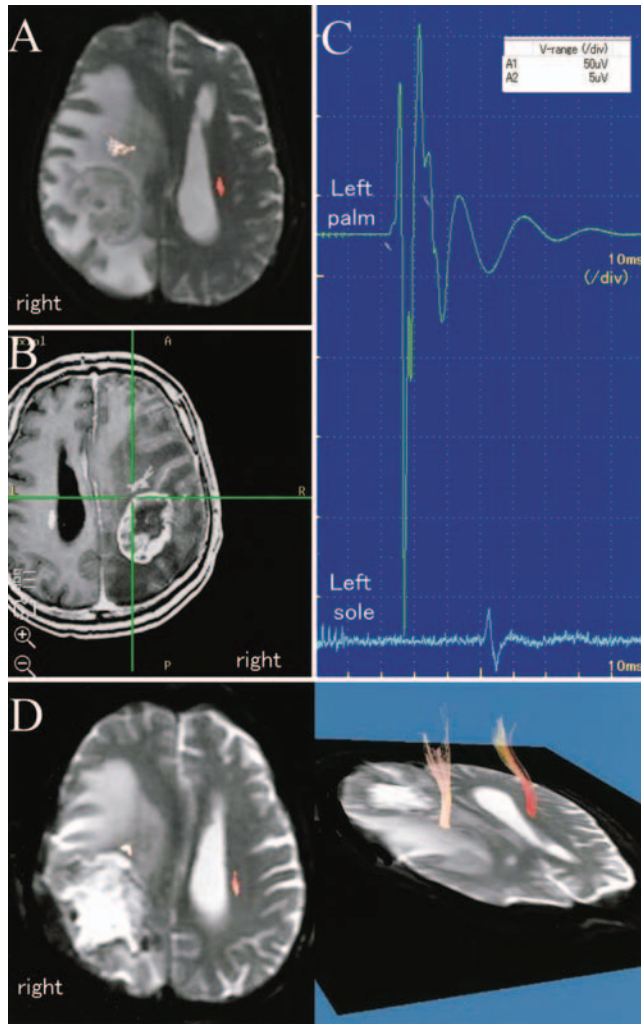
Case 6. A: Diffusion-tensor imaging–based tractography data indicating that the CST has shifted anteriorly. B: A T₁-weighted MR image from the functional neuronavigation system revealing the electrode position for fiber stimulation at the anterior wall of the resection cavity (green cross). C: Electromyogram demonstrating the MEPs in the palm and sole elicited by direct fiber stimulation at the anterior cavity wall. D: Postoperative T₂-weighted MR image with the superimposed CST demonstrating that the preserved CST remains anterior to the cavity.
